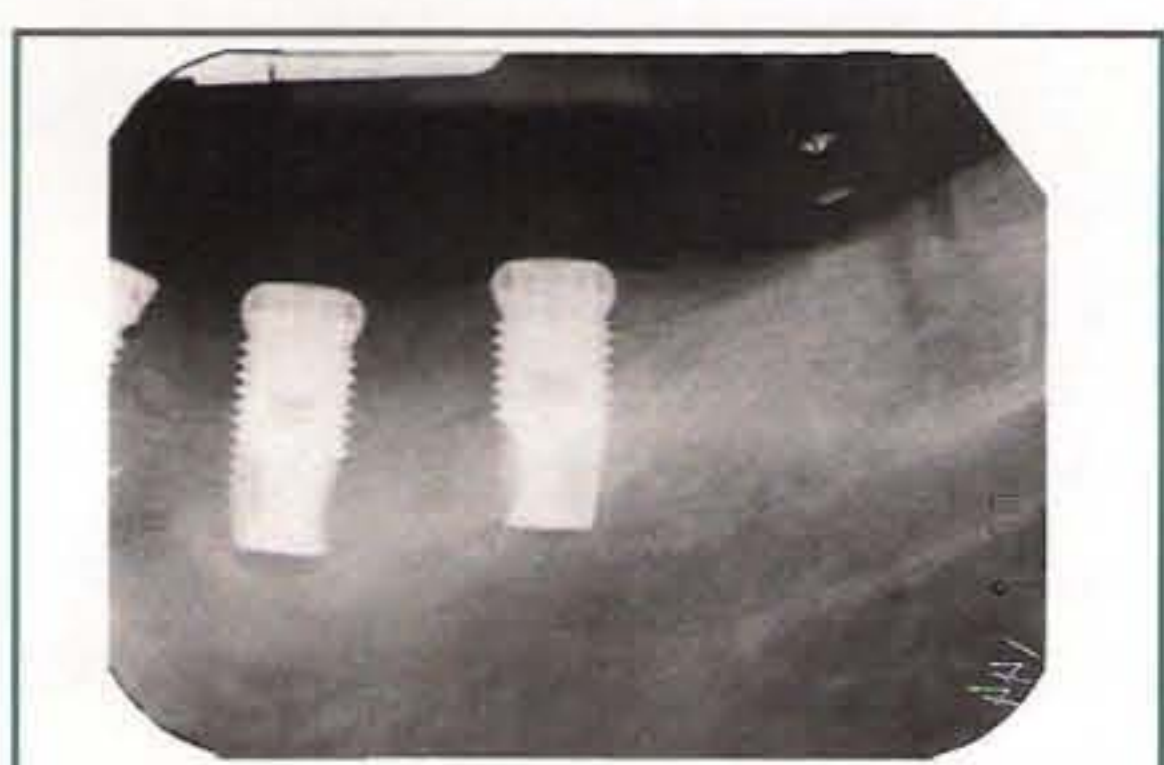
(far left) Radiograph of the implants.
